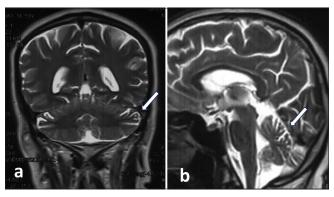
Brain magnetic resonance imaging (a) T2 coronal section (b) T2 sagittal section showing superior cerebellar atrophy.
